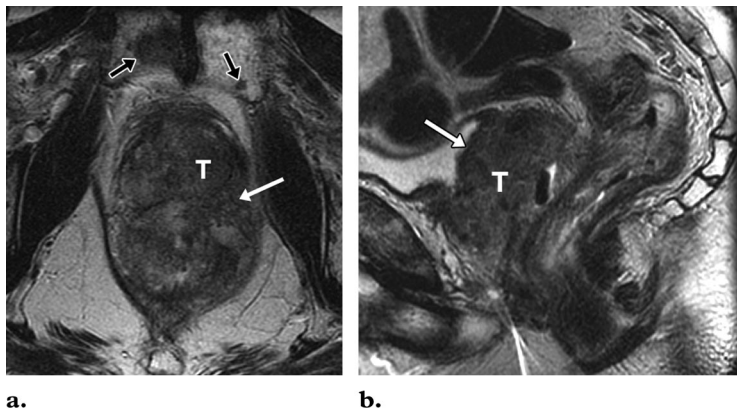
Biopsy-proved Gleason grade 7 adenocarcinoma in a 62-year-old man with a PSA level of 15.1 ng/mL. T2-weighted axial (a) and sagittal (b) MR images demonstrate diffuse tumor invasion of the prostate gland with direct tumor (T) extension to the wall of the urinary bladder and the anterior rectal wall (white arrow). The multiple low-signal-intensity lesions (black arrows in a) in the pubic bones are consistent with bone metastases.
